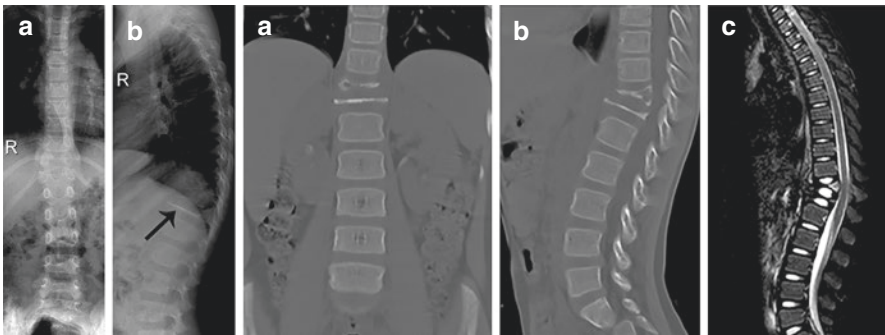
Eosinophilic granuloma (T11 and T12). Standard radiographs (a and b, left side, black arrow), CT scan (a and b, right side), MRI (c, right side)
